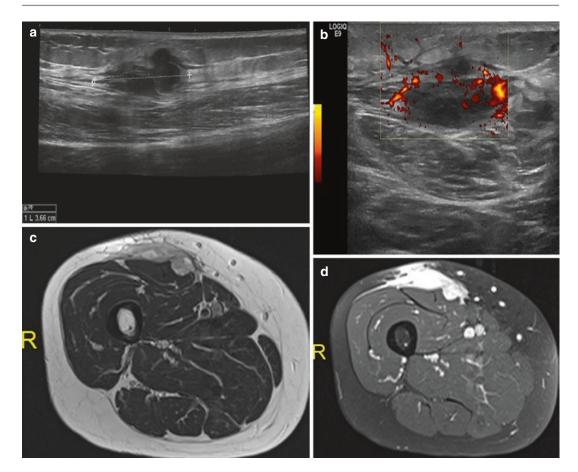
Myxofibrosarcoma in a 65-year-old female patient with painless firm mass at the right thigh. Demonstration of tumoral mass with nonspecific US characteristics for which further MRI examination and subsequent biopsy is mandatory. (a) Sagittal EVOFS US image demonstrating a nonhomogeneous hypoechogenic polynodular lesion centered and with a broad base at the superficial fascia of the rectus femoris, protruding into the subcutaneous tissue, maximal longitudinal diameter 3 cm (longest oblique diameter 5 cm). Indistinct borders with infiltrative aspect of the subcutaneous tissue. (b) Sagittal
